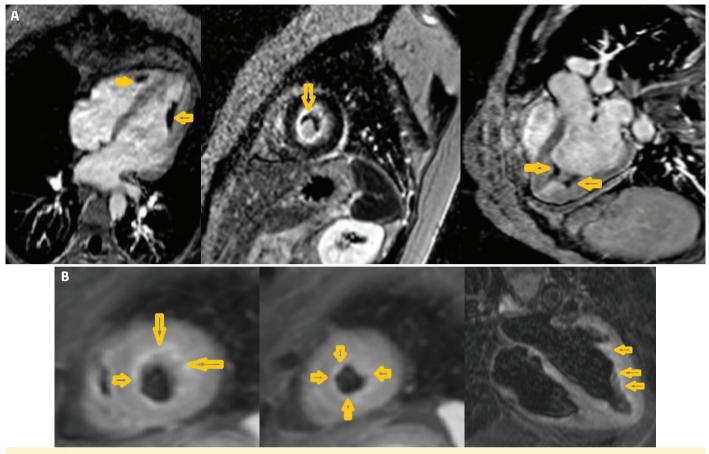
(A) Cardiac MRI images in short and long axis views showing late gadolinium hyperenhancement due to fibrotic changes in the apices of the left and right ventricles. (B) Cardiac MRI T2-weighted images reveal a hypersignal in the left ventricle's (LV) subendocardium, suggestive of edema from an inflammatory process.
